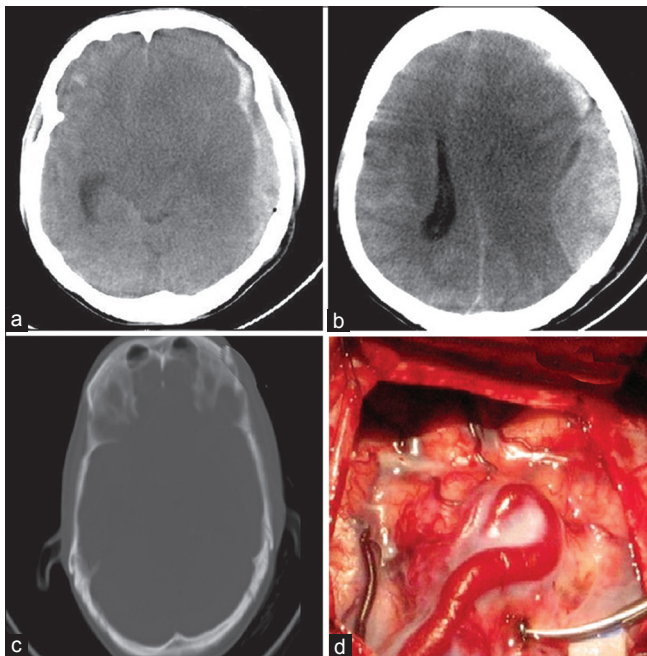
(a) Preop plain computed tomography axial image showing a thick left frontoparietal acute subdural hematoma. (b) Preop plain computed tomography axial image showing a left temporoparietal epidural hematoma. (c) Bone windows showing a left temporal linear fracture. (d) Intraop photo showing a lax brain after epidural hematoma and subdural hematoma evacuation and a grossly arterialized Sylvian vein
